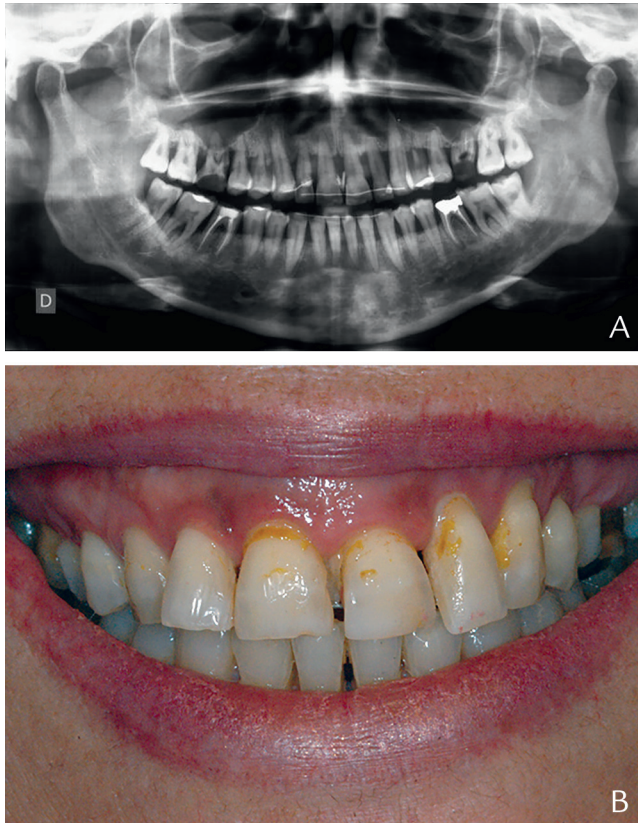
Pretreatment presentation. A, Panoramic radiograph. B, Extraoral image.
